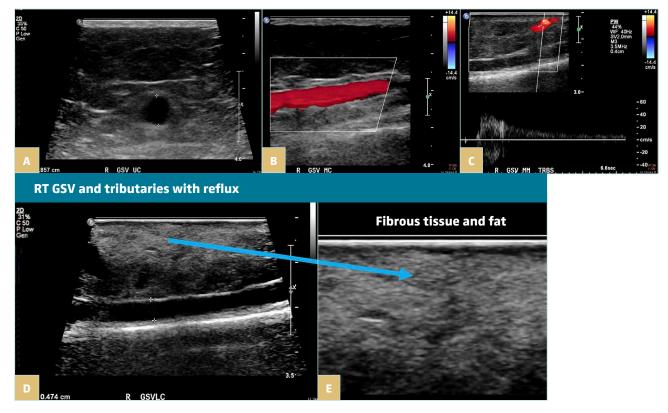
Ultrasound images of the great saphenous vein (GSV) and subcutaneous tissues. A) Enlarged GSV diameter in the upper cuff measuring 8.6 mm. The subcutaneous tissues have normal echotexture at this level. B,C) Reflux is shown in a GSV tributary at the medial malleolus. D) GSV in the distal calf was enlarged measuring 4.7 mm. The echotexture of the subcutaneous tissues here is abnormal, showing dense fibrosis. E) Magnified view of the subcutaneous tissues showing dense fibrous tissue and pockets of fat.
